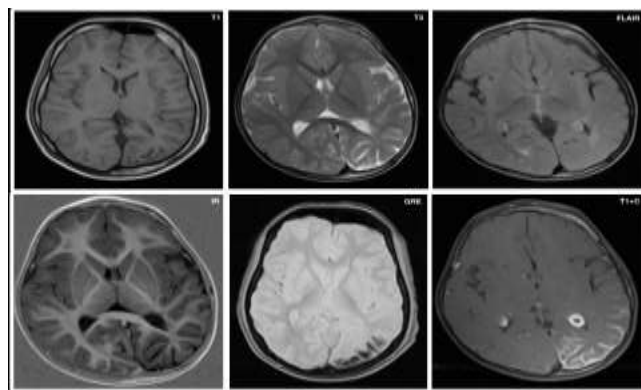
A 2 year old male with Sturge Weber syndrome: Hemiatrophy of the left side with enlarged subarachnoid spaces and subtle FLAIR hyperintensity along the sulci of the left parietooccipital lobes was seen. On inversion recovery (IR) image, volume loss could be appreciated. There is blooming seen on GRE image suggestive of calcification. On post contrast image, there is serpentine pial enhancement along cortical sulci and gyri of left parieto-occipital lobes with thickened and enhancing ipsilateral choroid plexus.
